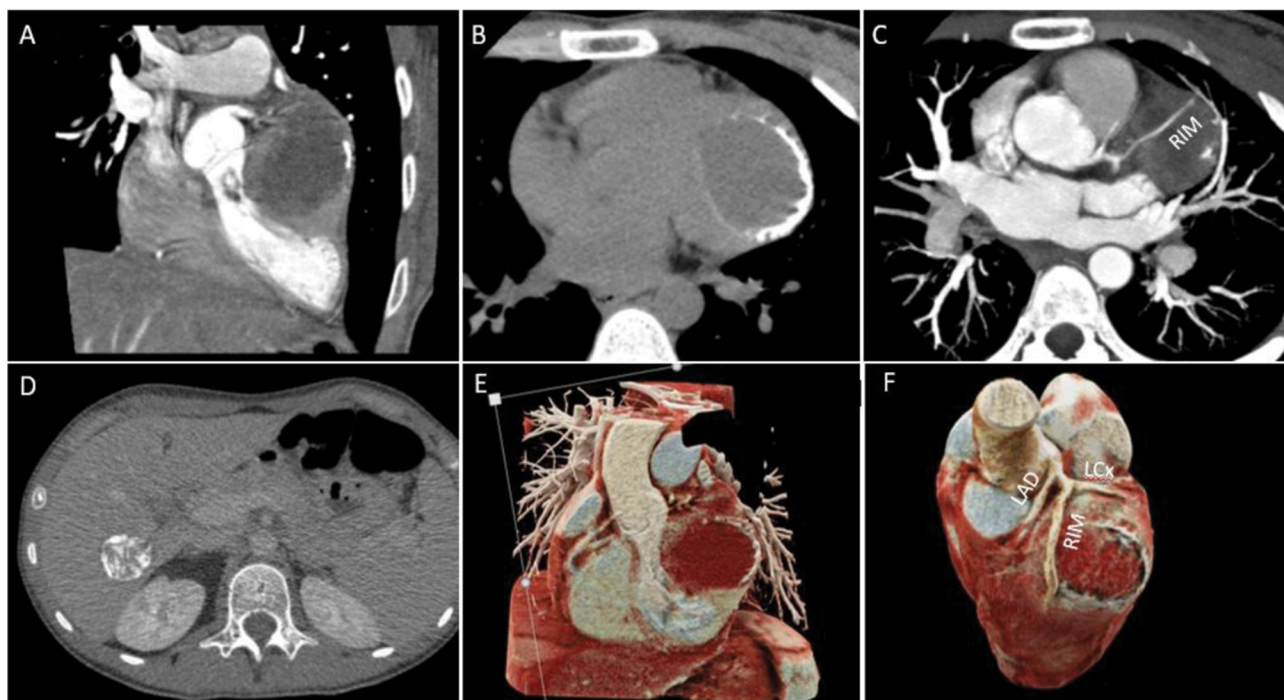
Computed tomography demonstrating the cystic lesion in the heart, located in the left ventricle lateral wall with additional 3D cinematic VRT. The typical peripheral calcifications are well demonstrated (B). RIM passing over the cyst (C). Liver lesion with typical water-lily sign is also shown (D). A coronal view of the cyst (E) and volume rendering of coronary arteries (F). LAD: left anterior descending artery; LCx: left circumflex artery; RIM: ramus intermedius.
